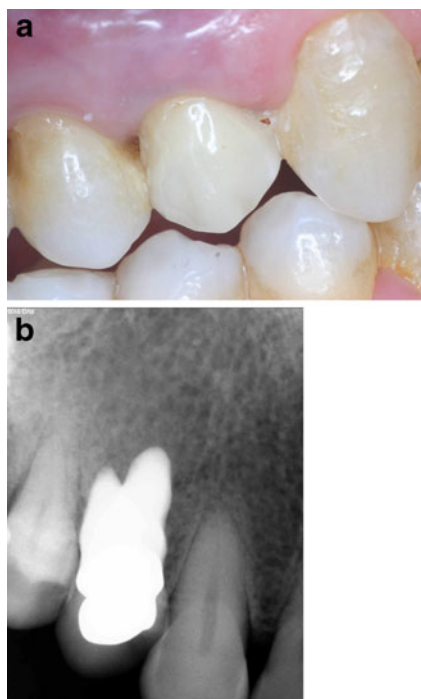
a The definitive restoration in situ 1 year after implant placement. b x-ray at 1-year follow-up with the RAI and crown in situ
